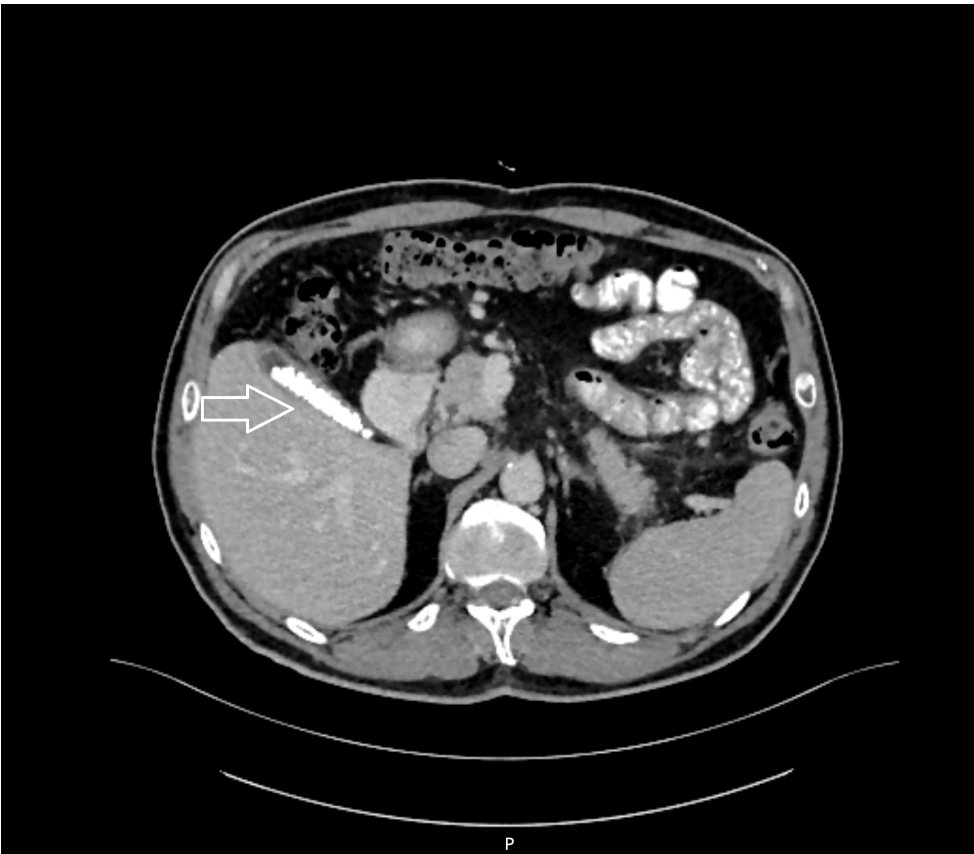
Transverse sectional view of the calculus in the gallbladder and inflamed gallbladder wall in the CT scan.
